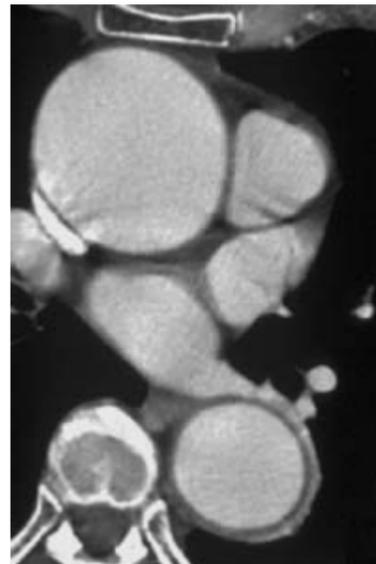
Pre-operative CT section of a patient with simultaneous aneurysms of the ascending arch and descending aorta.
